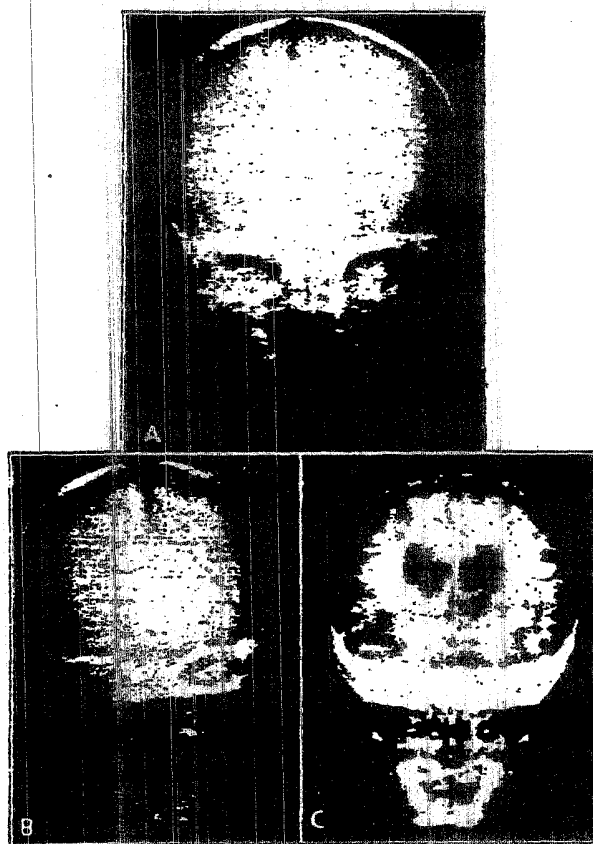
A, roentgenogram of the skull of R. M., on her admission to the hospital. No abnormality is noted. B, roentgenogram of the skull three weeks after admission, showing the sutures widely separated. C, encephalogram seven weeks after the onset and three weeks after the subsidence of symptoms of lead encephalitis. Cerebral atrophy is evidenced in the markedly enlarged ventricles and the excess of air over the cortex of the brain.
